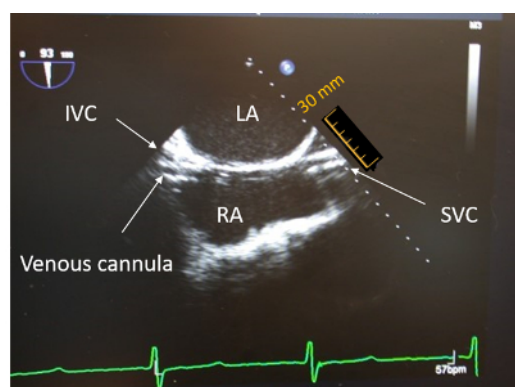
Bi-atrial view by transesophageal echocardiography. The venous cannula is inserted percutaneously through the right femoral vein and placed through the inferior vena cava (IVC) up to the origin of the superior vena cava (SVC) (1 mm in scale = 2.9 mm). LA = left atrium, RA = right atrium. [Please click here to view a larger version of this figure.](#)
